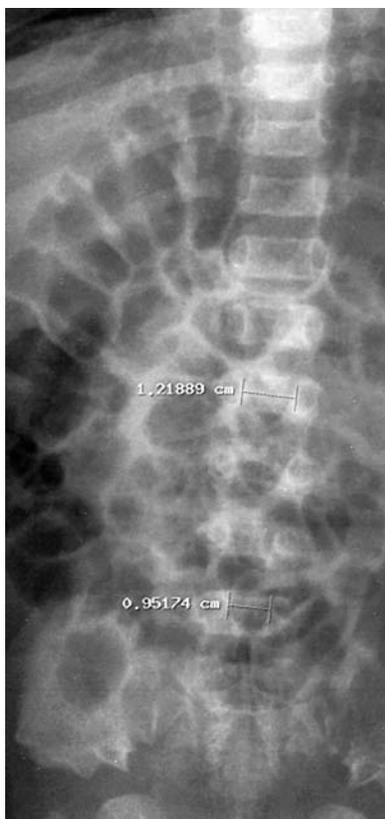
An anteroposterior radiograph of the lumbar spine of a child with achondroplasia is shown. The characteristic narrowing of the interpediculate distance from L1 to L5 (widening is the normal pattern) can be seen. The small rounded iliac wings and narrow sacrosciatic notches also typical of achondroplasia can be seen.
